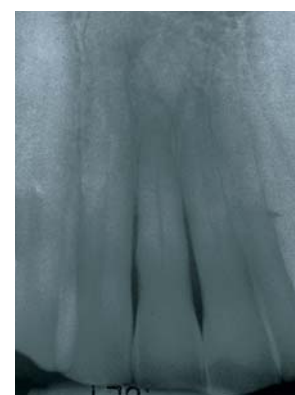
Radiograph of lower incisors taken in October 2000 before placement of splint and restorative work. Notice the extent of bone loss around central incisor tooth Nos. 24 and 25.
